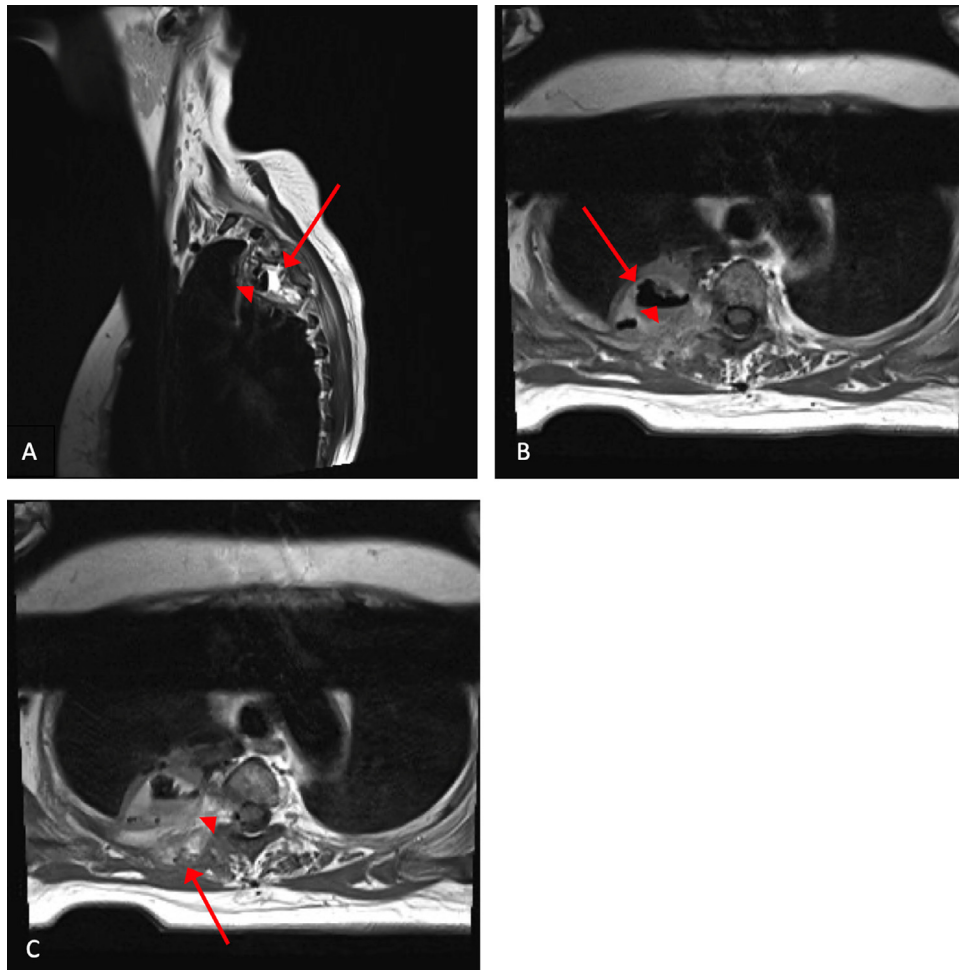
Multi sequence MRI of the thoracic spine: (A, B) Well-defined heterogeneous signal intensity cavitary lesion at the right paravertebral region at the upper-level T3 down to lower T4 level (arrows). (C)The lesion showed erosion and involvement of the adjacent posterior right T3-4 with extension posteriorly into the right posterior paraspinal region (arrow). There is limited right neural foramina extension at the T3-4 level (arrowheads). However, no intraspinal extension.
